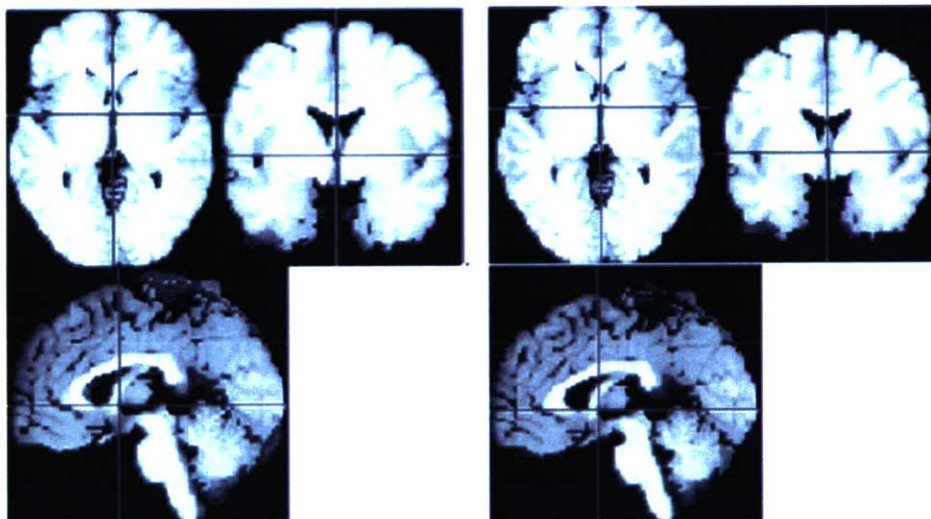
Mean images after high dimensional warping control subjects and schizophrenics. *Left:* The mean image of warped MR images obtained from 76 controls. Even after averaging, the mean image is not blurred. *Right:* The mean image of warped MR images obtained from 47 schizophrenics. The mean image of schizophrenic looks similar to that of controls.
